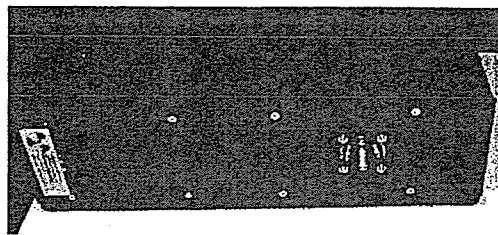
X-ray tube unit.
